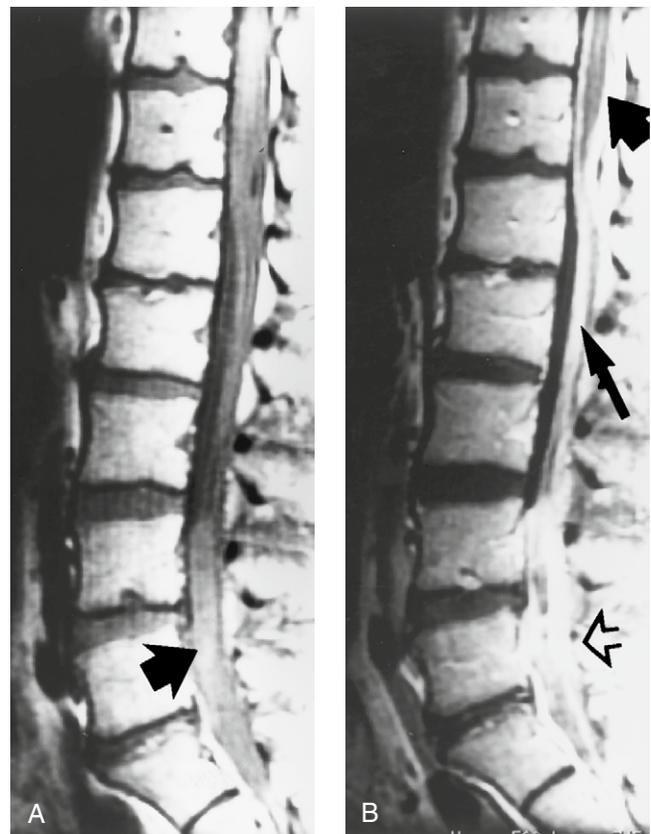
Spinal *Coccidioides* meningitis. (A) Non-enhanced sagittal T1-weighted image shows abnormal increased signal in the lower lumbosacral thecal sac (arrow). (B) Sagittal T1-weighted image with gadolinium shows intense abnormal enhancement coating the conus medullaris (arrow) and the cauda equina (long arrow). The lower lumbosacral thecal sac shows abnormal diffuse enhancement (open arrow).
